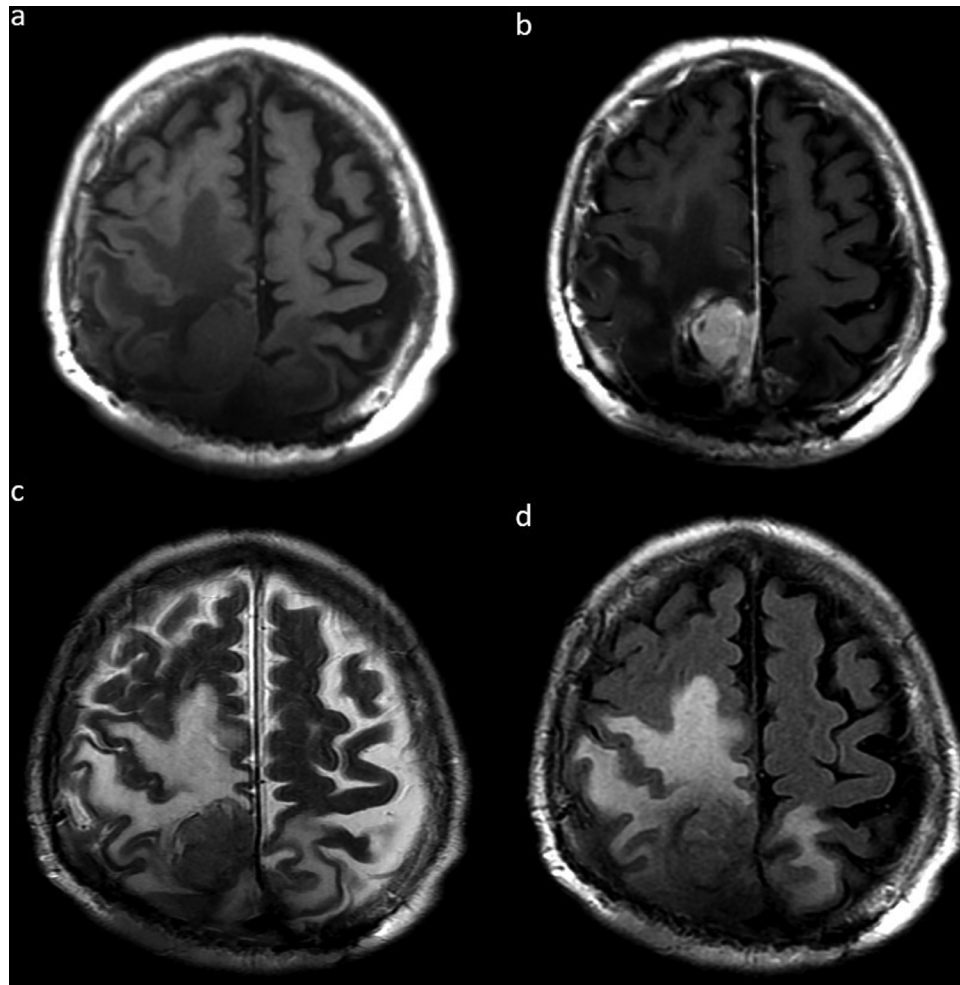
(a-d). An MRI was performed with nongadolinium-enhanced T1 (a), gadolinium-enhanced T1 (b), T2 (c), and FLAIR (d) sequences and revealed an extra-axial mass measuring 6 × 3 × 3.5 centimeters in the occipital region with extracranial extension into the subgaleal space. The mass was heterogeneously enhancing. There was heterogeneous signal within the calvarium also adjacent to the calvarial defect through which the mass extended extra-cranially. Hemorrhage was present along the inferior aspect of the mass. Compression and displacement of the adjacent right occipital lobes was noted with right hemispheric subdural hemorrhage and subarachnoid hemorrhage in the parietal sulci
